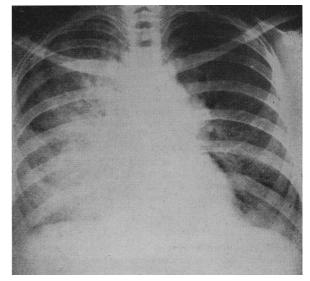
Case 2. Radiograph taken on 6 July 1962, three months before death.
